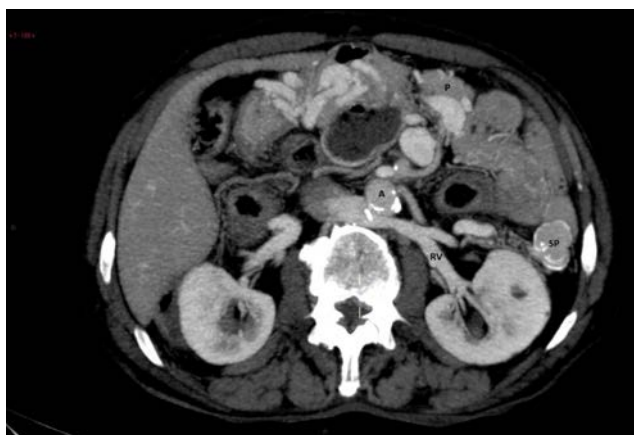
The abdominal computed tomography (CT) scan showing the aorta (A), the spleen (SP), the head of the pancreas (P) and the renal vein (RV).
